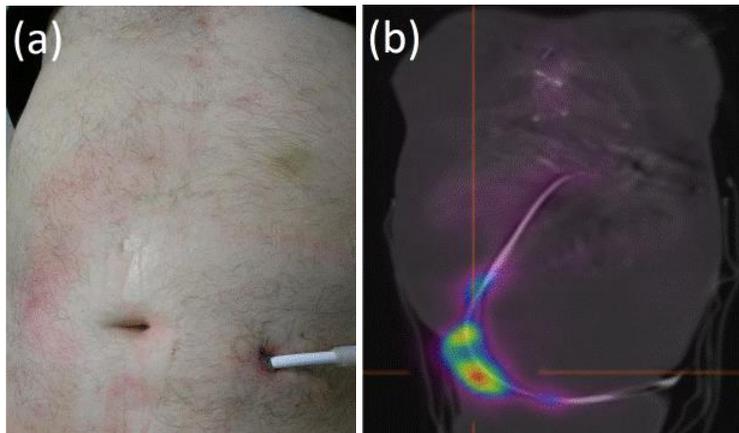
(a) Patient with driveline infection; note erythema tracking along abdominal wall. (b) Gallium-67 single-photon emission computed tomography (Ga SPECT-CT) of the same patient confirming the presence of infection limited to the driveline.
